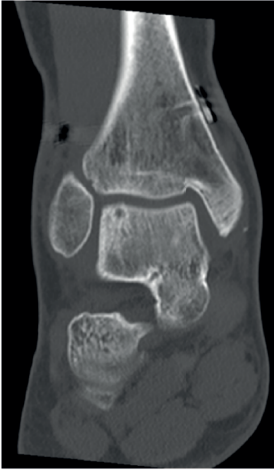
Postoperative CT scan of an operatively treated pronation-external rotation type ankle fracture with additional fixation of a Bernd and Harty type III osteochondral lesion with 2 smart screws.
